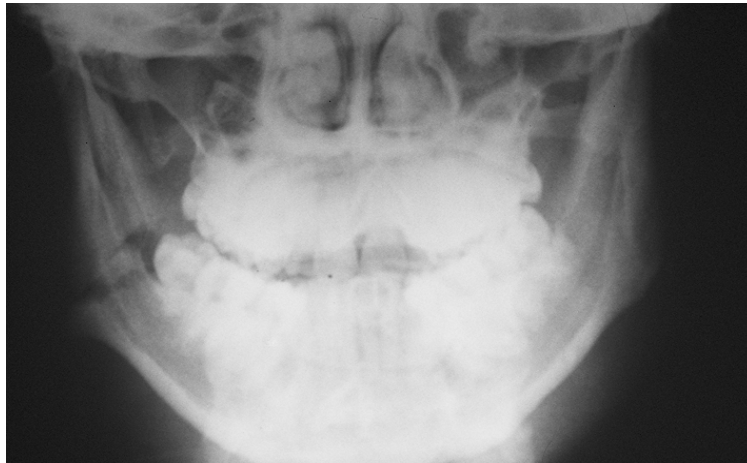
Initial X-ray, fracture at the right angle of mandible
